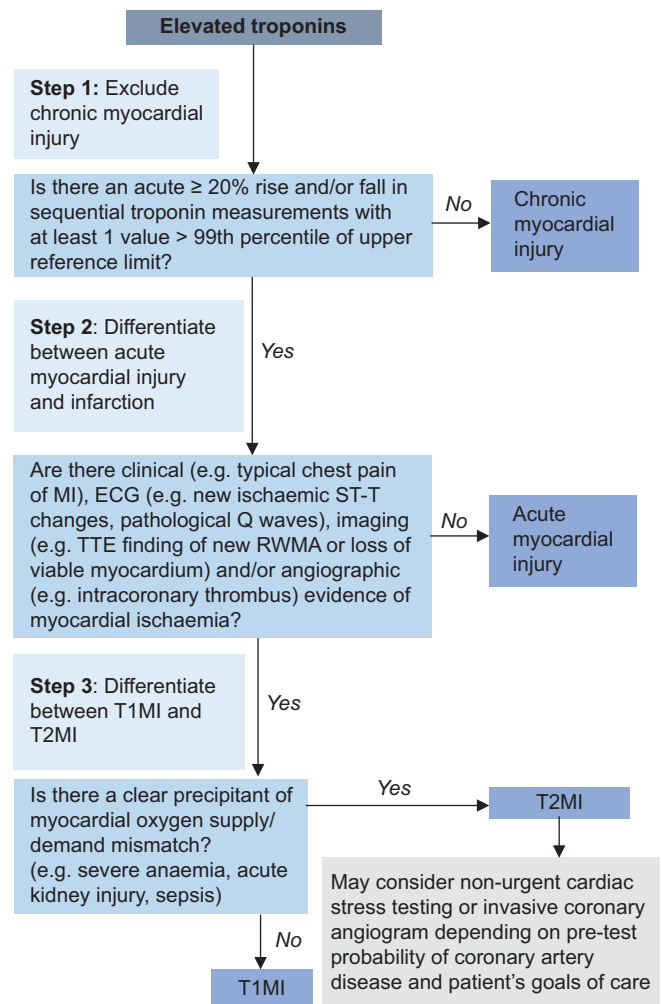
Chart shows a ‘three-step’ approach to hypertroponinaemia. T1MI: type 1 myocardial infarction, T2MI: type 2 myocardial infarction, TTE: transthoracic echocardiogram
